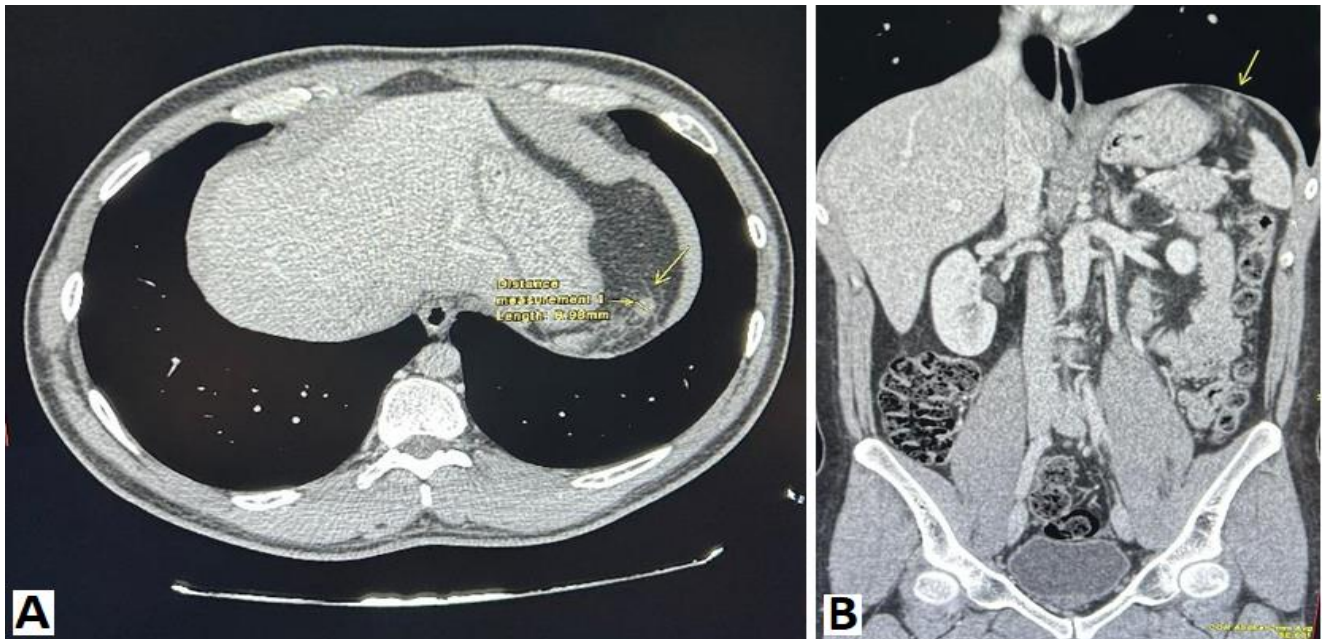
(A and B): Axial view and coronal view of contrast enhance CT scan showing AS surrounded with fat stranding (arrow).
